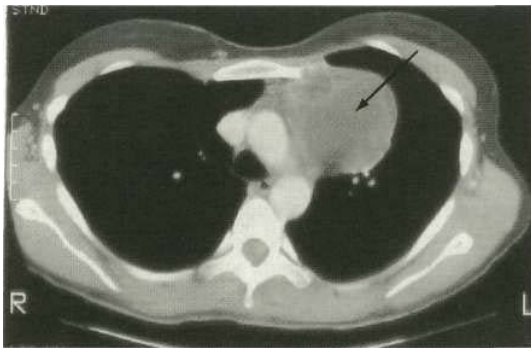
CT scan of a dermoid cyst in the mediastinum.
